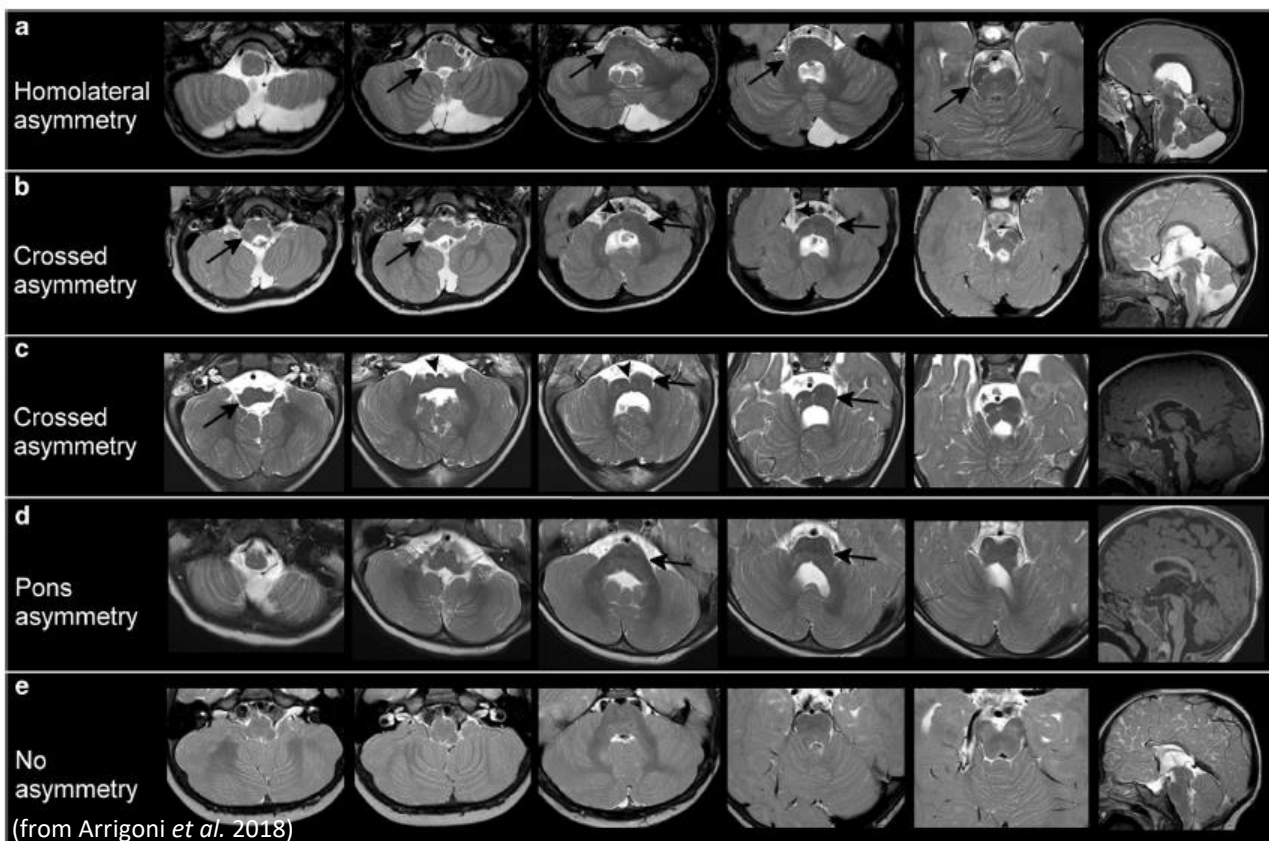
Patterns of brainstem asymmetry. Midline Axial T2-weighted sections of the brainstem, from the medulla to the mesencephalon, of five patients with different patterns of brainstem asymmetry are shown in each row. Sagittal T1 and T2-weighted sections are shown in the last column of each row. Patient A has an ipsilateral asymmetry with an enlargement of the right portion of medulla, pons and right cerebral peduncle (arrows in a). Patients B and C carry mutations on different genes (*TUBB3* and *TUBA1A* respectively) but share the same pattern of crossed brainstem asymmetry (right medulla > left medulla; right pons < left pons) (arrows in b and c) and an anterior midline cleft (arrowheads in b and c). Patient D shows an isolated pontine asymmetry (arrow in d), while patient E has no asymmetry.
